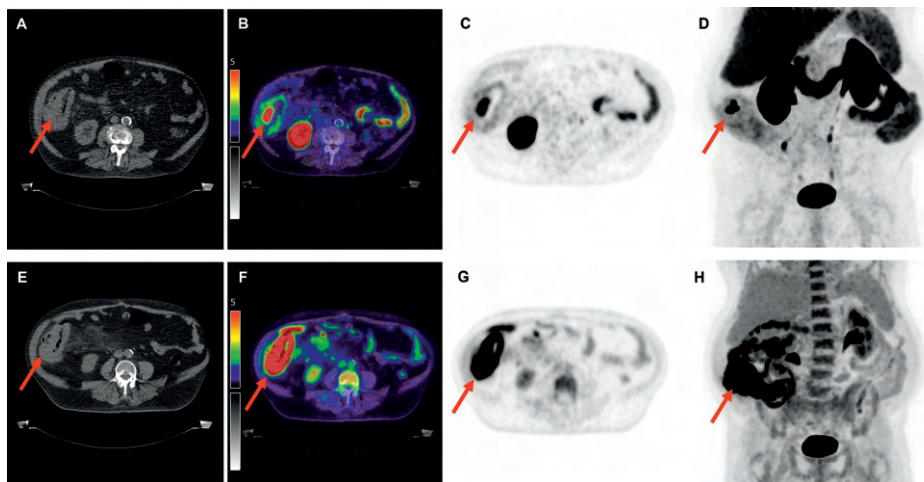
Overview of imaging modalities of a patient with pT3N0M0 colon carcinoma (patient 1). The arrows indicate (upper row) a lesion with intense $[^{18}\text{F}]\text{DCFPyL}$ expression with an SUV_{max} of 9.9 and (bottom row) a lesion with $[^{18}\text{F}]\text{FDG}$ uptake with an SUV_{max} of 45.5. From left to right: low-dose CT (A,E), fused PET/CT (B,F), PET (C,G), and the maximal intensity projection (MIP, (D,H)). Image scale SUV 0-5.
